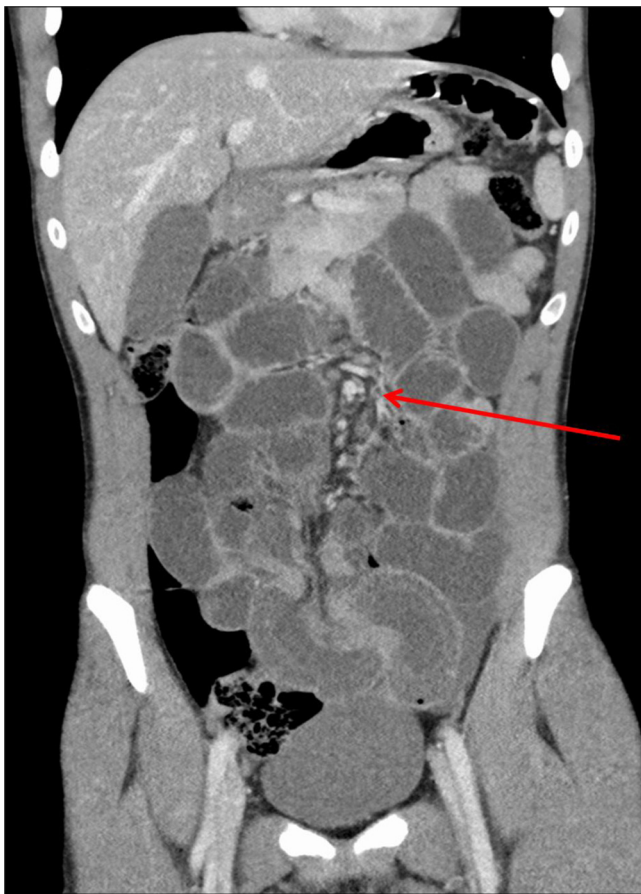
Contrast enhanced computed tomography scanning image demonstrating mechanical small bowel obstruction with a transition zone (arrow).
